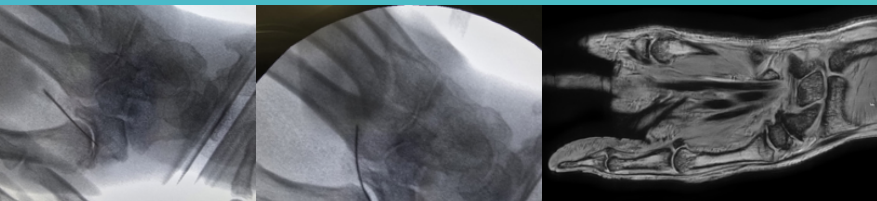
14: Pre- and post-interventional X-rays are also shown, as well as the 12-month MRI follow-up. There is insufficient data regarding the treatment of rhizarthrosis to draw a meaningful conclusion.
